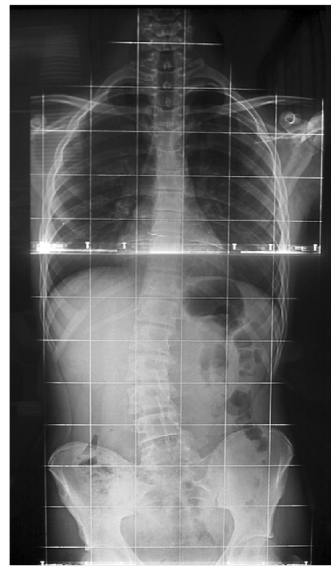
X-ray of the spine showing scoliosis.
